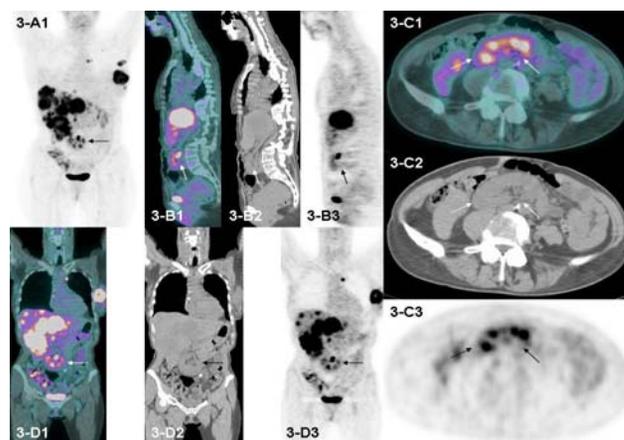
Anterior view (3-A1) of maximum intensity projection shows horizontal abdominal ectopic kidney (arrow); axial fused (3-C1), CT (3-C2) and PET (3-C3) images, sagittal fused (3-B1), CT (3-B2), and PET (3-B3) images, coronal fused (3-D1), CT (3-D2) and PET (3-D3) images show horizontal ectopic right kidney (arrows).
